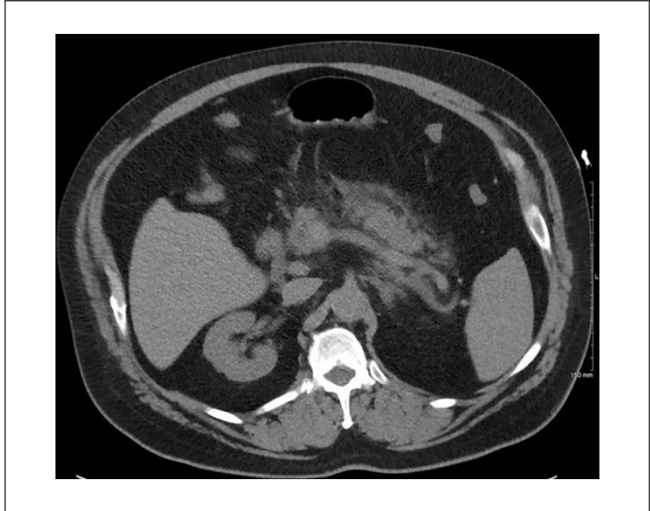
Computed tomography (axial view) scan of abdomen showing diffuse peripancreatic inflammatory changes and fat stranding.
